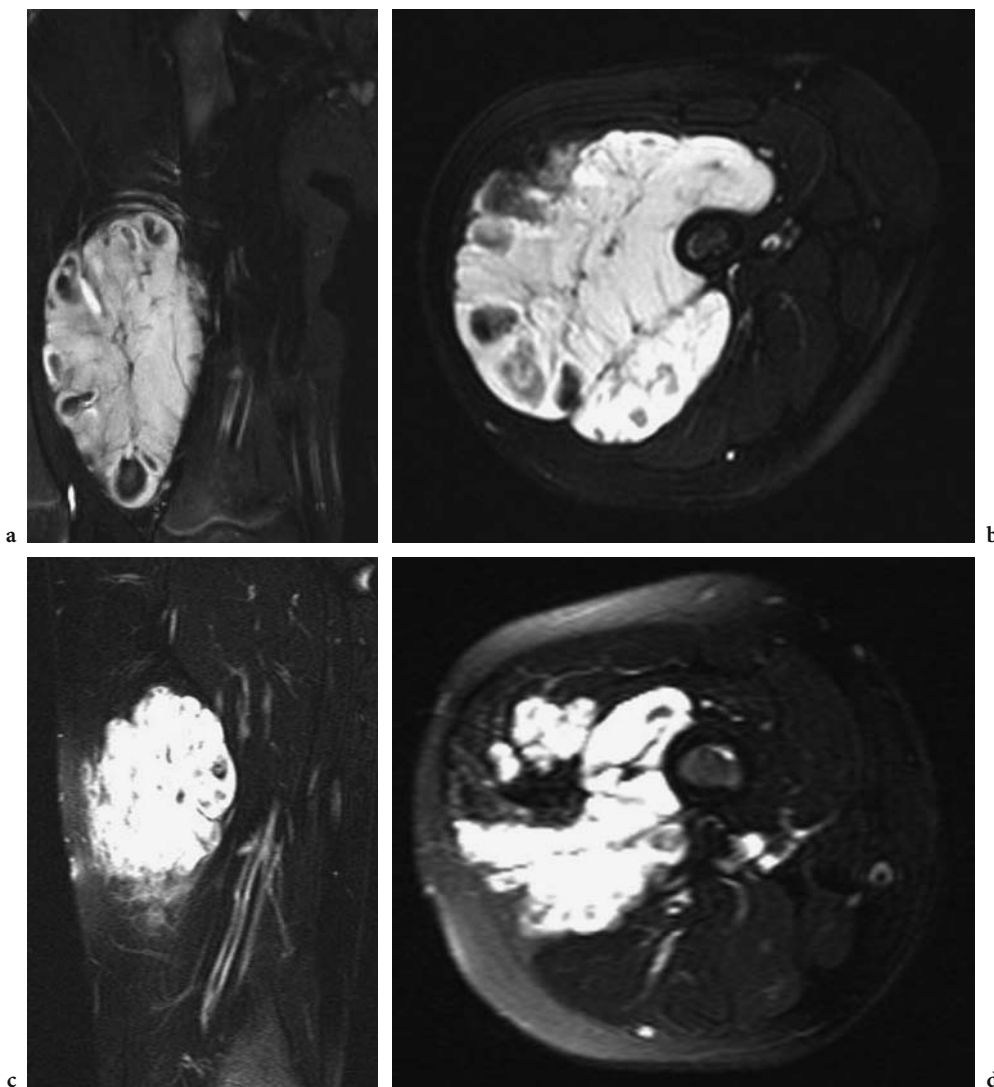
Four-year-old boy with venous malformation of the thigh. a Coronal and b axial T2SE MRI show a well delimited intramuscular venous malformation. Six months after three sessions of sclerosing treatment with alcohol c coronal and d axial T2SE show an important regression
